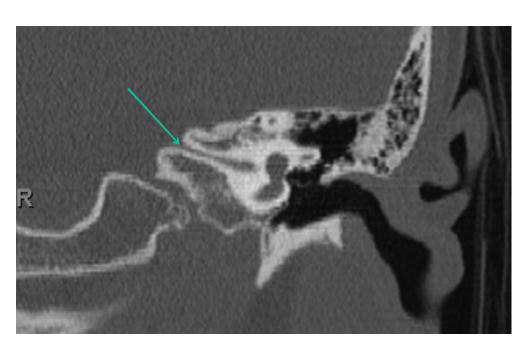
Coronal CT scan demonstrating a normal right internal auditory canal in Subject 1 (image on the left) and a narrow left internal auditory canal (image on the right).
